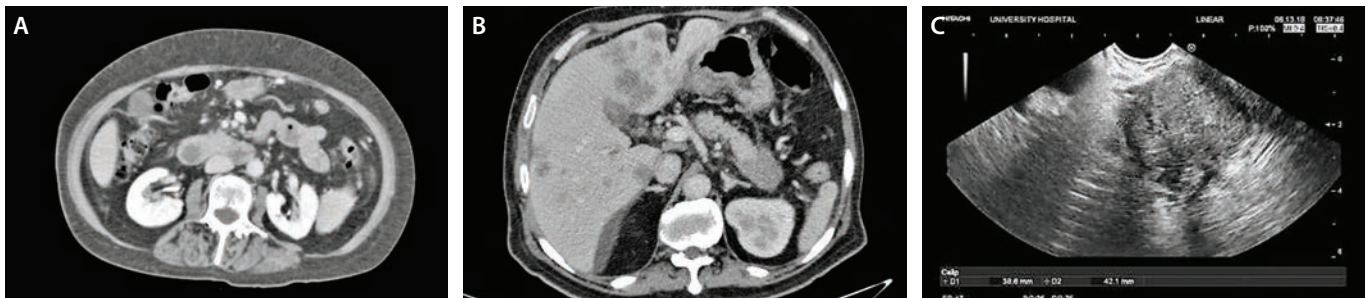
Pancreatic adenocarcinoma. Computed tomography scan shows the usual location and variegated, ill-defined appearance of a tumor in the head of pancreas (a). Another case with tumor in the tail demonstrating, as is often the case with tumors outside the head, multiple hepatic metastases (b). Endoscopic ultrasound shows an ill-defined heterogeneous mass typical of adenocarcinoma (c).
